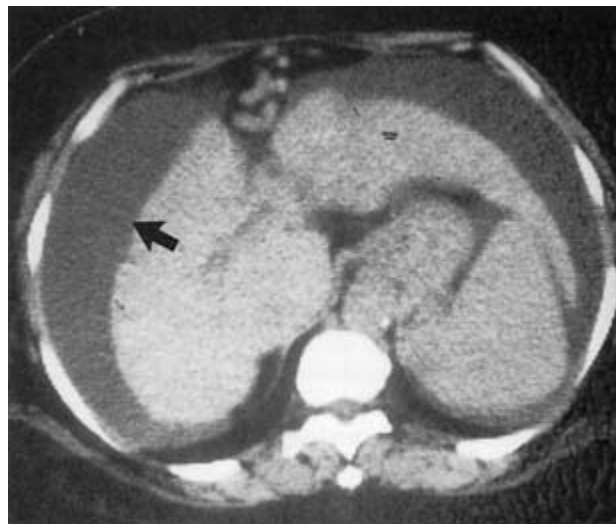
CT scan showing an irregular cirrhotic small liver, splenomegaly and ascites (arrow).
